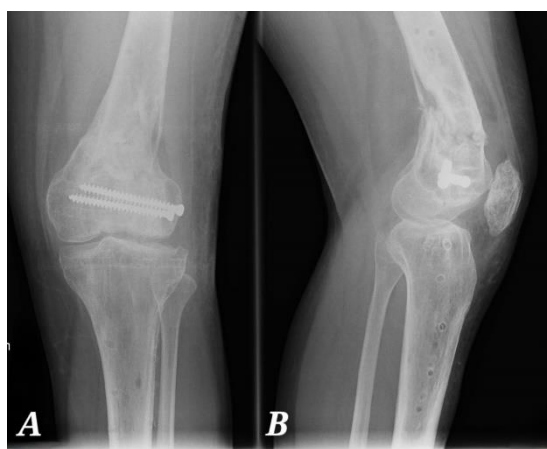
A: AP radiography shows severe osteoarthritis in the lateral compartment. B: LAT radiography shows a non-union femoral supracondylar region with osteoarthritis changes in the patellofemoral joint
